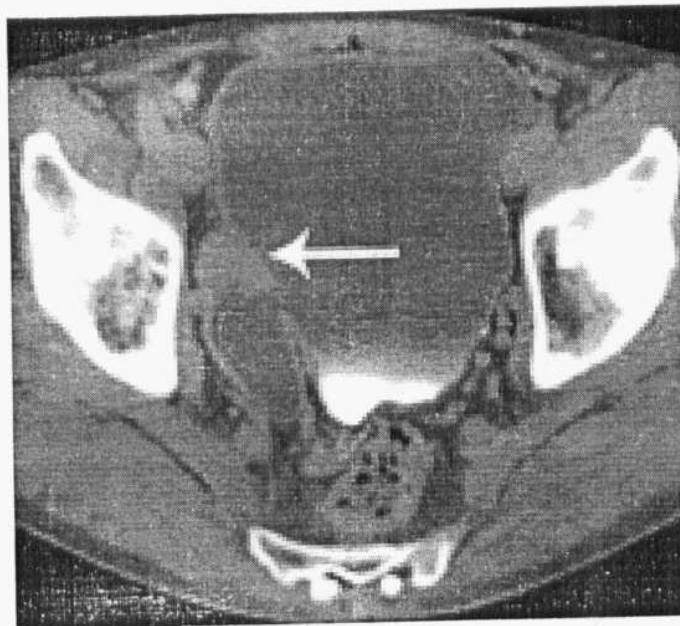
Diverticular tumor. Axial CT image shows a urothelial tumor (arrow) within a bladder diverticulum. Urinary stasis occurs with bladder diverticula, thus predisposing them to tumor development.
